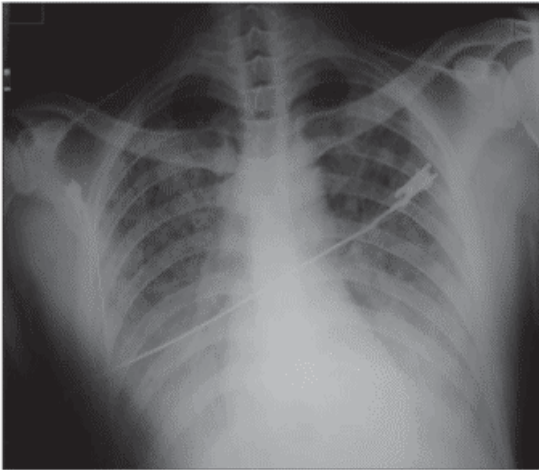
Chest radiograph after discontinuation of CPAP
